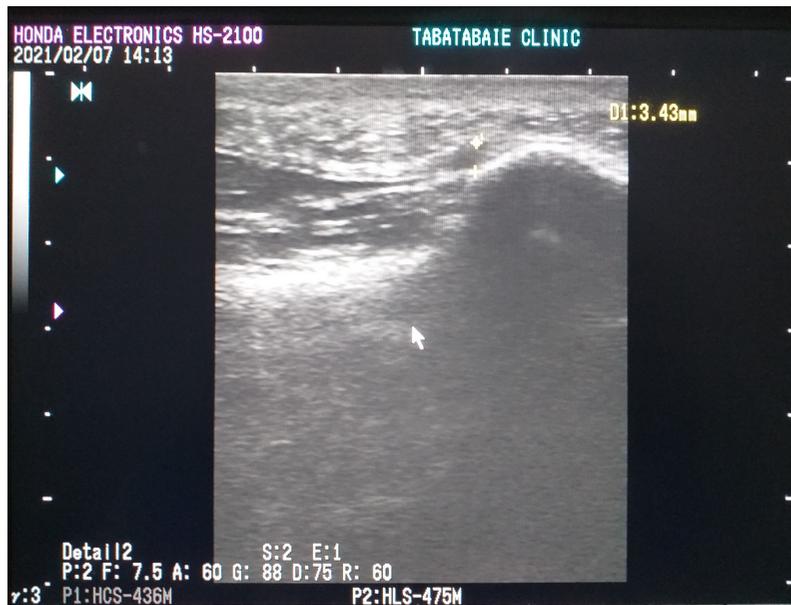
Sonographic imaging of plantar fasciitis patient
